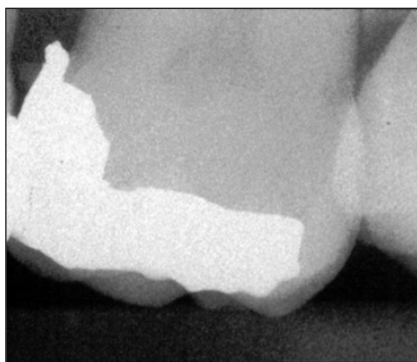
Preoperative radiographic image of tooth #3 MO.
